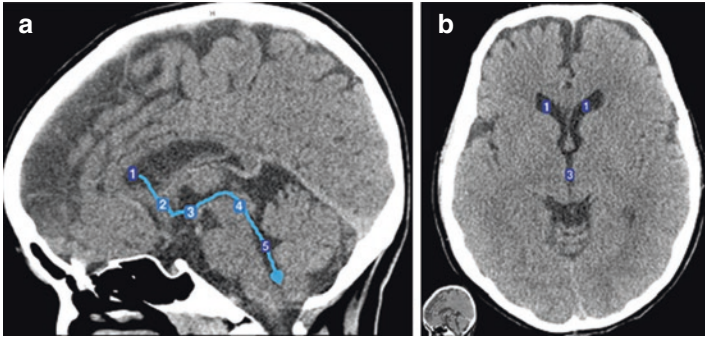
(a) Sagittal view of a non-contrast CT scan showing the path of the CSF from the lateral ventricle (1) passing via the foramen of Munro (2) and entering the little slit like third ventricle (3) and from thence through the Aqueduct of Sylvius (4) to reach the final enlargement in the ventricular system, the fourth ventricle (5). The ventricles can be likened to a cave inside the brain which contains water that flows from 1 to 5 and out through the foramen of Magendie. (Heart shaped arrow tip indicating that the fluid eventually returns to the heart.) (b) Is an axial view of a non-contrast CT scan of the brain showing how the frontal horns (1) of the lateral ventricles pass through the foramen of Munro to reach the third ventricle (3)
